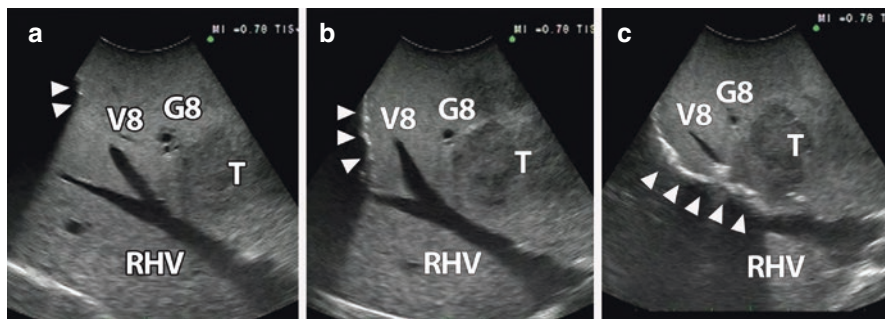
Intraoperative ultrasound guidance to resection. (a) The section line (arrowheads) of a laparotomic Sg8 segmentectomy is approaching the right hepatic vein (RHV) with too smooth an angle, at the level of a Sg 8 venous branch (V8). (b) The section line direction has been corrected, now running below V8, then (c) reaching the RHV, allowing a safer margin with the tumor (T)
